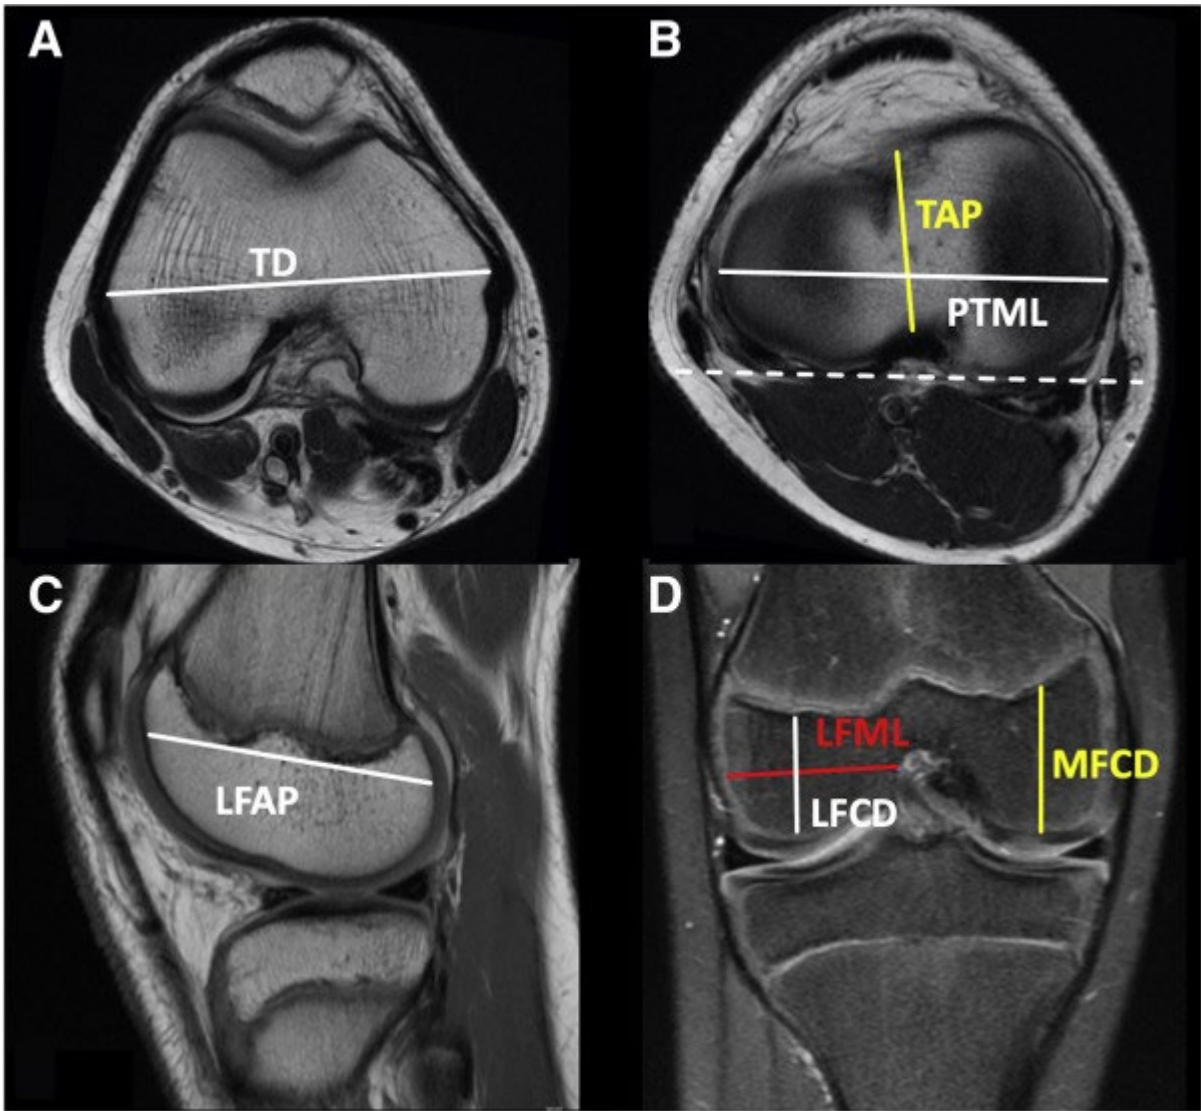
Two-dimensional (2D) measurements on 2D magnetic resonance imaging of a right knee: (A) transepicondylar distance (TD, white line), measured on axial cuts; (B) on axial the axial cuts, the proximal tibia mediolateral dimension (PTML, white line) parallel to the posterior tibial condylar axis (white dotted line), and the tibial plateau antero-posterior dimension (TAP, yellow line) were measured. (C) On the sagittal cuts, the lateral femoral condyle anteroposterior dimension (LFAP, white line) was measured. (D) On the coronal cuts, the lateral femoral condyle mediolateral dimension (LFML, red line), the lateral femoral condyle craniocaudal dimension (LFCD, white line), and the medial femoral condyle craniocaudal dimension (MFCD, yellow line) were measured.
